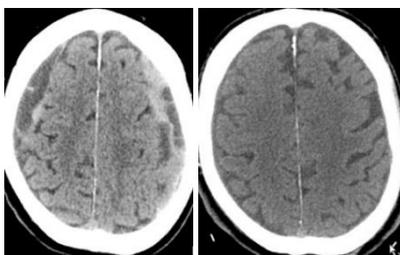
Left: Initial non-contrast CT head demonstrating bilateral subdural collections with significant septations. Right: Non-contrast CT head at 9 months follow up, with complete resolution of the previous bilateral CSDH associated with significant septations.
